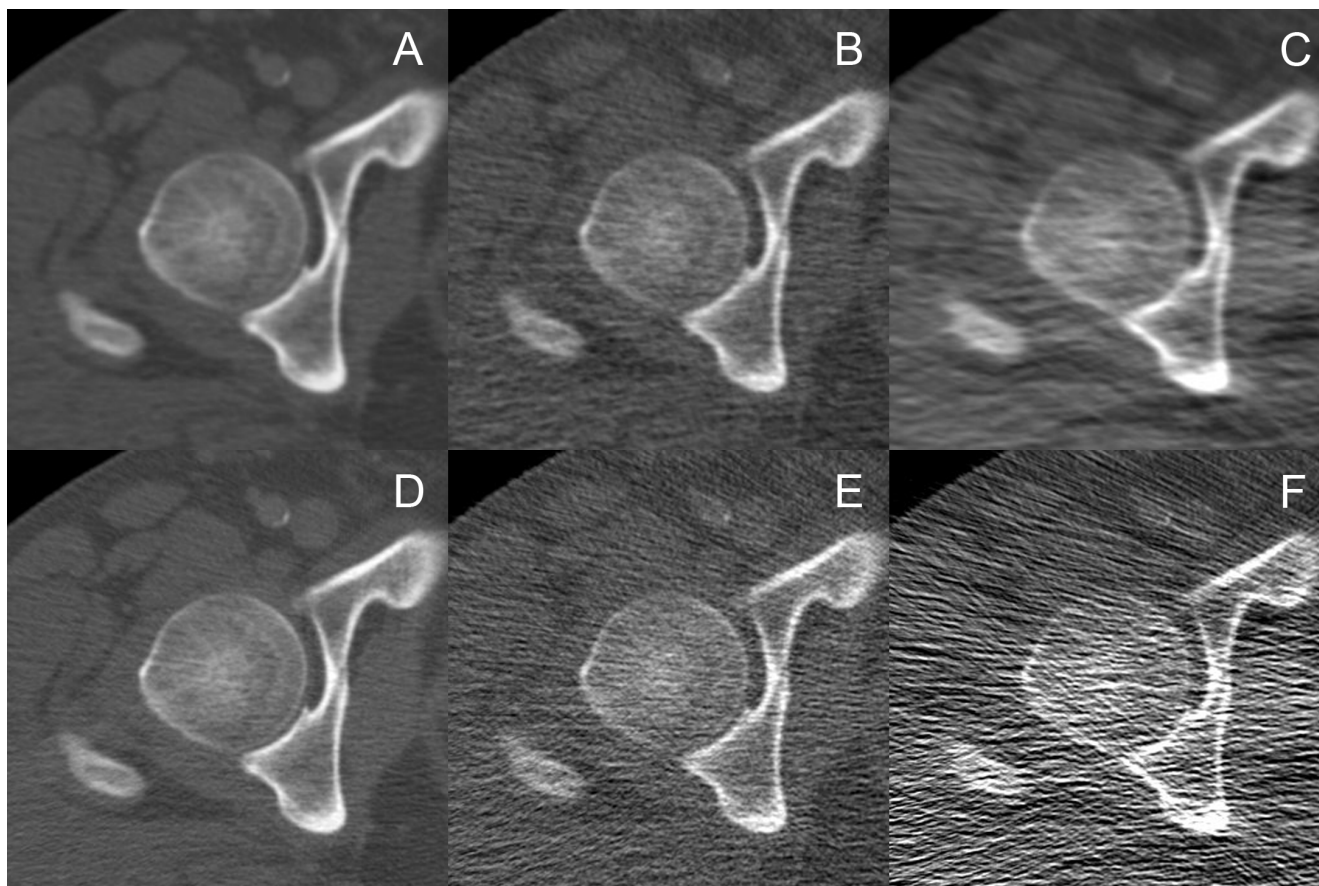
Low dose and ultra-low dose images of a patient's right femur head. A, B and C (1st row) are reconstructed with iterative reconstruction (SIR) and D, E and F (2nd row) are reconstructed with filtered backprojection (FBP). A and D (left column) are the original low dose images. B and E (middle column) are the 10% sparse sample images, while C and F (right column) are the corresponding images with 10% tube current. SIR and sparse sampling have great potential to mitigate artefacts and to quantitate bone density in ultra-low dose musculoskeletal CT imaging. (Window level 300 HU, width 1500 HU.)
